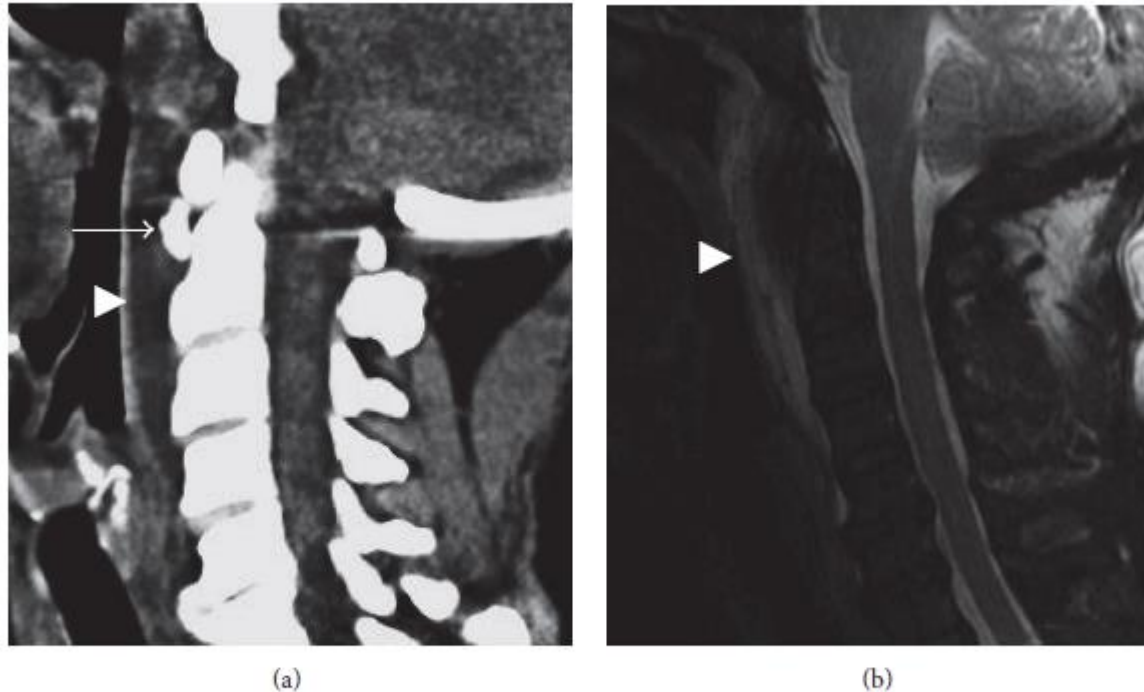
Calcific tendinitis of the longus colli. (a) Sagittal CT showing rounded calcification anterior to the dens just below the C1 anterior arch (arrow). Prevertebral edema causes anterior bowing of the pharyngeal mucosa (arrowhead). (b) Prevertebral edema is more conspicuous on sagittal T2 fat-suppressed image (arrowhead). The calcification of the longus colli tendon is not well appreciated on MRI.
